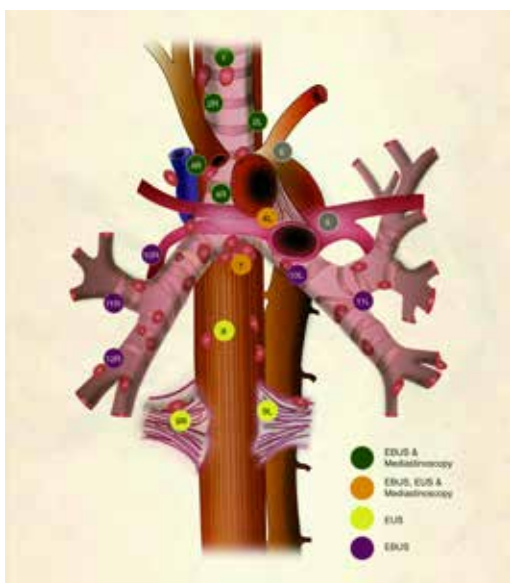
Lymph node map adapted from the 2009 IASLC lung cancer staging project. The lymph node stations are color coded to indicate the minimally-invasive staging techniques that can readily access each lymph node station. The close proximity to vascular structures highlights the importance of direct visualization or ultrasound guidance to avoid bleeding complications. EBUS, endobronchial ultrasound; EUS, endoscopic ultrasound; IASLC, International Association for the Study of Lung Cancer.
